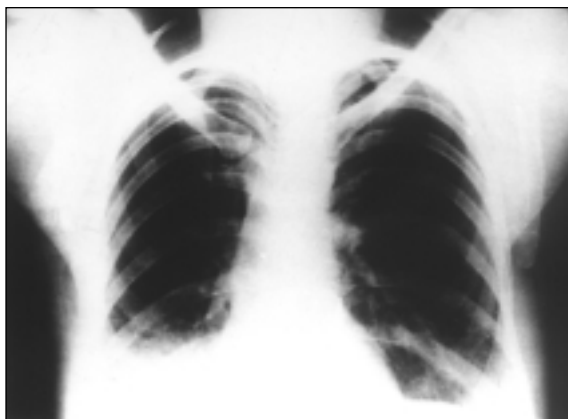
Chest radiograph shows consolidation in lower zone of right lung.
